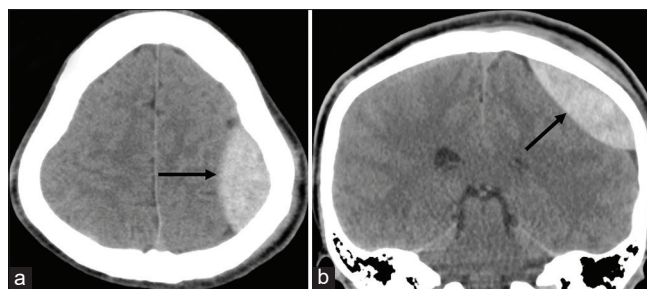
Axial (a) and coronal (b) computed tomography scans performed 12 h after the admission showing the growth of the hematoma with an increased thickness of 25 mm (arrow).
